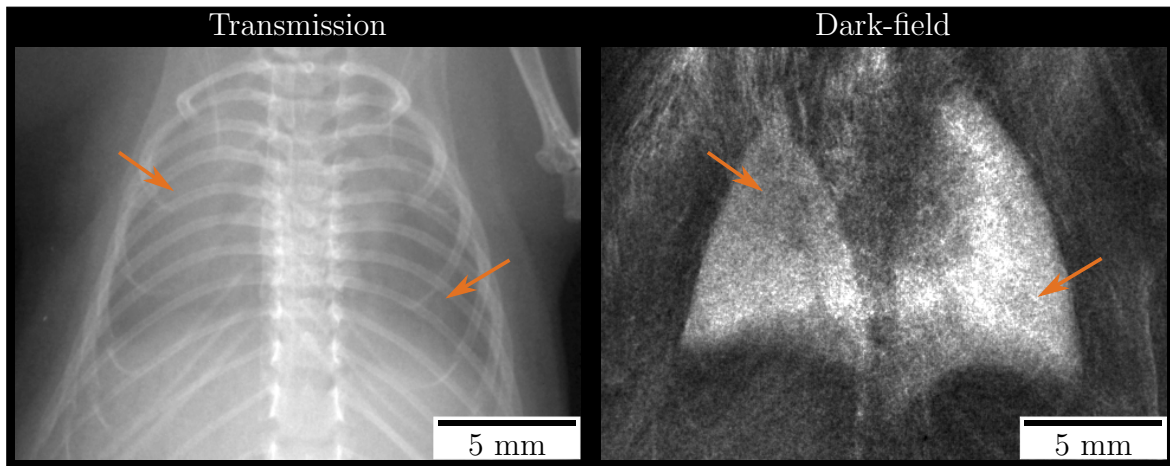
Typical radiography of *in-vivo* transmission and dark-field imaging for the detection of lung nodules. Overlying structures like the bones, spine, diaphragm, heart (left, transmission), and the fur (right, dark-field) impede the diagnosis and a localization of the tumors, which are indicated by the arrows, with high sensitivity is not possible. Both figures are color-scaled for best visual appearance.
